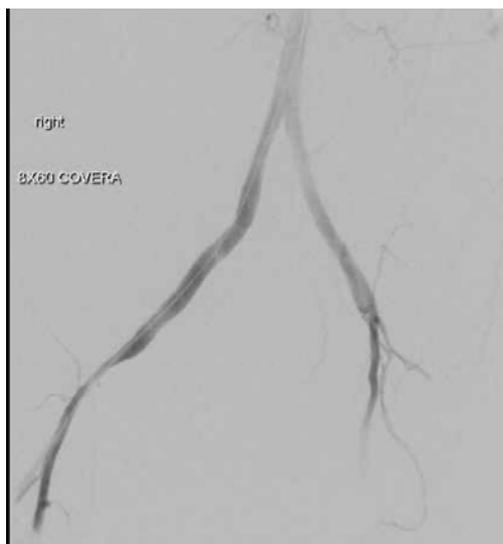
CT Aortography shows right common iliac artery after repair with an 8mm self-expanding Covera stent graft.
